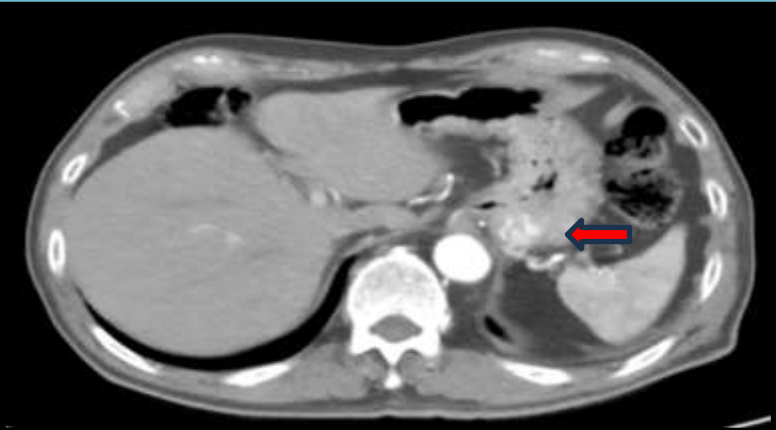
CTA with arrow showing AVM at gastric fundus
